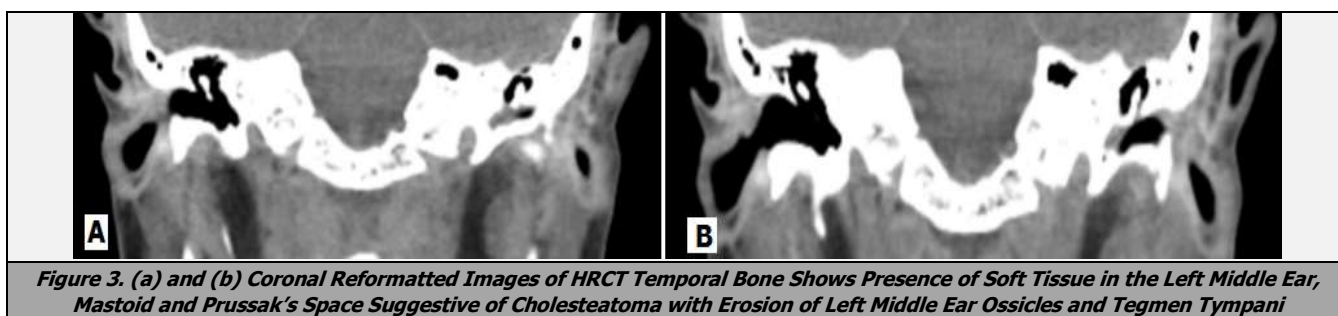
(a) and (b) Coronal Reformatted Images of HRCT Temporal Bone Shows Presence of Soft Tissue in the Left Middle Ear, Mastoid and Prussak's Space Suggestive of Cholesteatoma with Erosion of Left Middle Ear Ossicles and Tegmen Tympani
